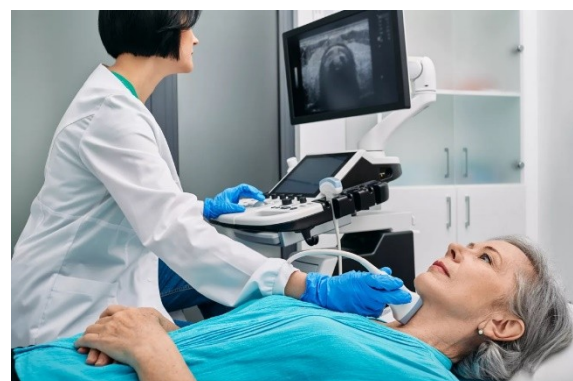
medical ultrasound [21].
